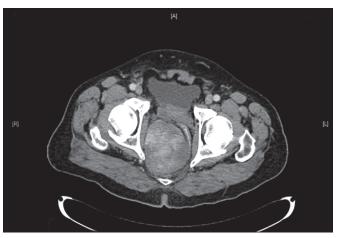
Computed tomography of the chest, abdomen, and pelvis showing a large right lower pelvic mass, whose nature is not clear
